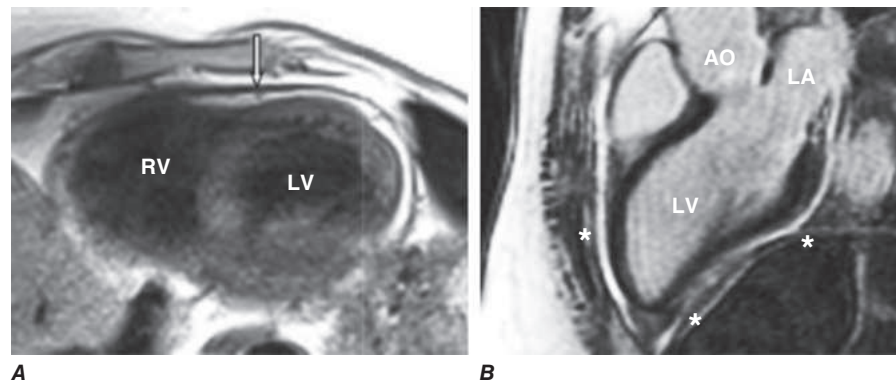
Pericardial inflammation by cardiac magnetic resonance imaging. A. Short axis view. The pericardium is thickened and enhanced on T2 magnetic images. Note thickened white line denoted by arrow. B. Long axis view. Late gadolinium enhancement of thickened, inflamed pericardium. AO, aorta; LA, left atrium; LV, left ventricle; RV, right ventricle. (From RY Kwong: *Cardiovascular magnetic resonance imaging*, in Braunwald's *Heart Disease*, 10th ed, Mann DL et al [eds]. Philadelphia: Elsevier, 2015, pp 320–40.)
